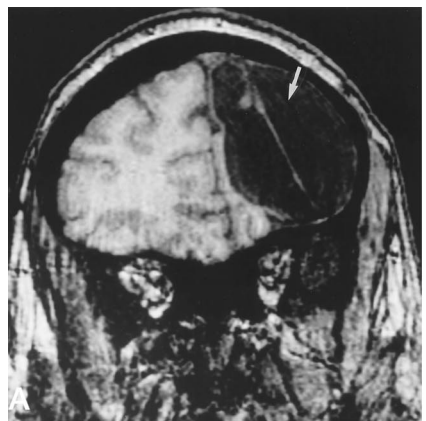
Case 1. Noncontiguous volumetric T1-weighted MR images (20/6.2/1) in the coronal plane show a left porencephalic cyst in the distribution of the left internal carotid artery (*arrow*). This arterial territory is identifiable by involvement of the cortex supplied by the middle cerebral territory, as well as by involvement of the posterior limb of the internal capsule and the posterolateral white matter, which are supplied by the anterior choroidal artery.
